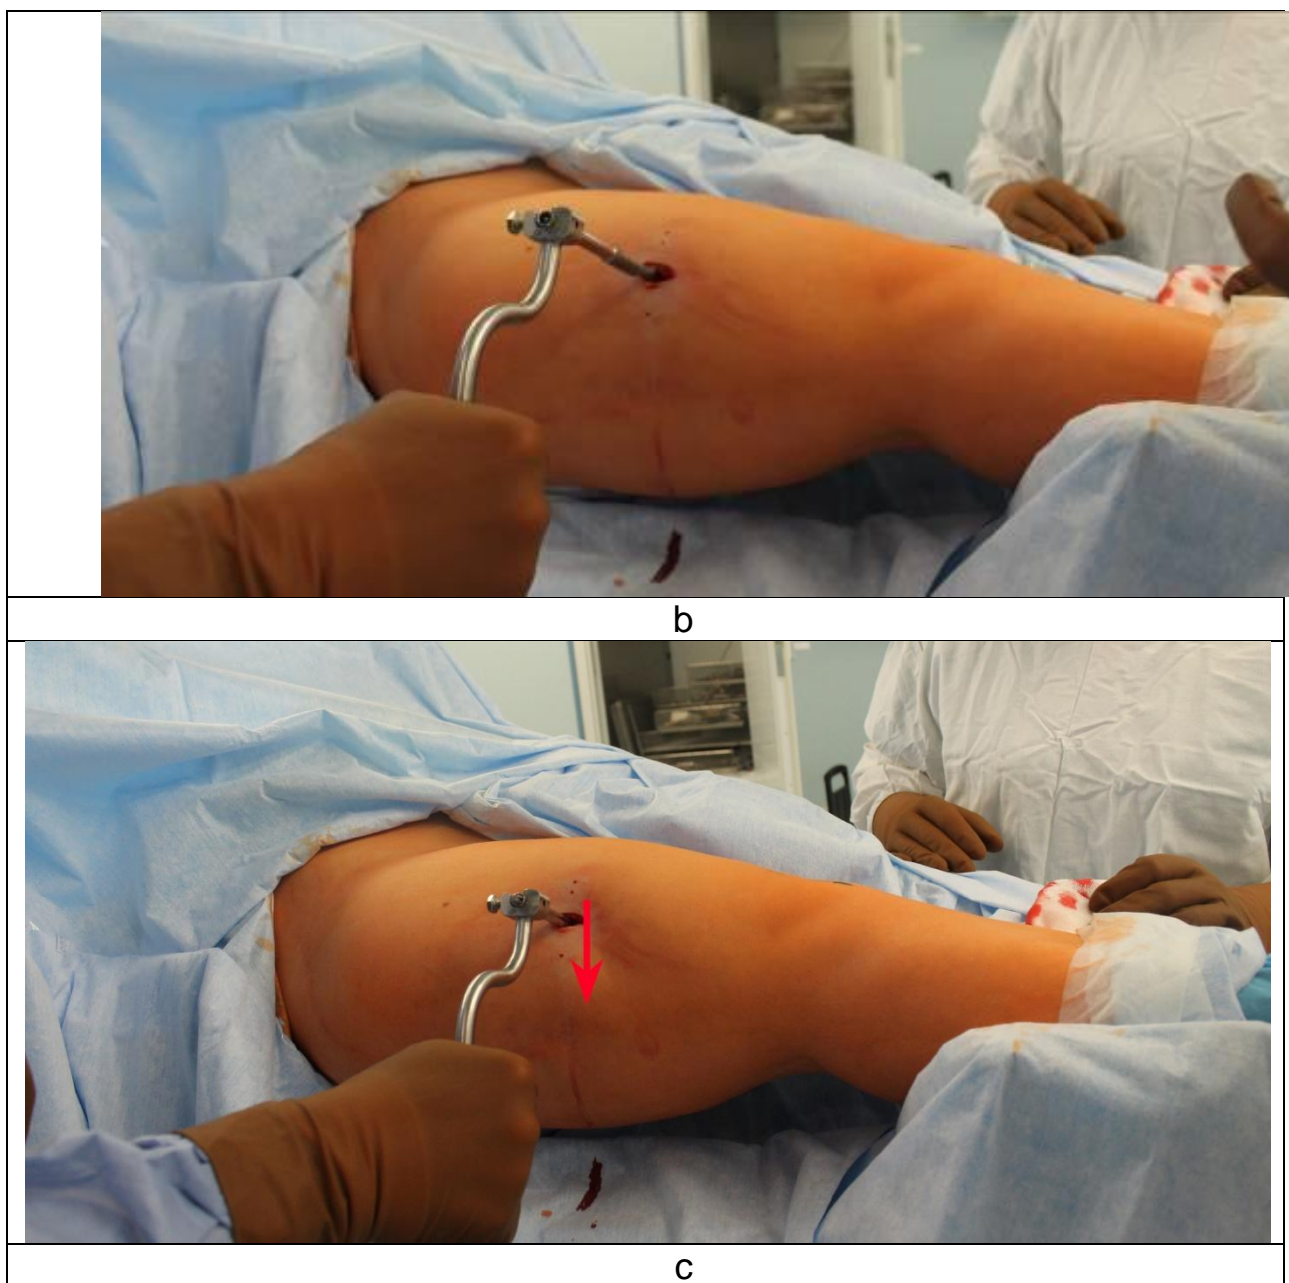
Insertion of SUV-clamp: a – T-shaped part of SUV-clamp in connection with Instrument #2; b – T-shaped part is immersed fully into the soft tissues till the stop at bone; c - manually performed pressure on the shank of the T-shaped part of SUV-Clamp towards the bone (pointed by arrow)
